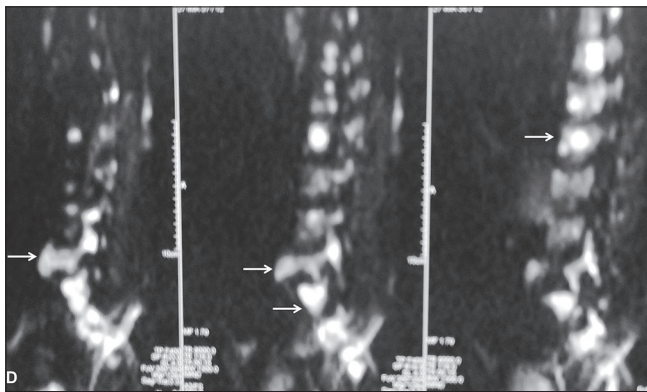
Pathological fracture in patient with multiple myeloma. Sagittal T1 W (a), T2 W (b) and post-contrast (c) MR images show severe fracture at L5 level with complete vertebral collapse and soft tissue component bulging posteriorly causing compression of cauda equina (arrow). Multiple other vertebrae show altered signal intensity and enhancement. Diffusion weighted images obtained at b-value of 1000 (d) show restricted diffusion at L5 and in sacrum and in other lumbar vertebrae
